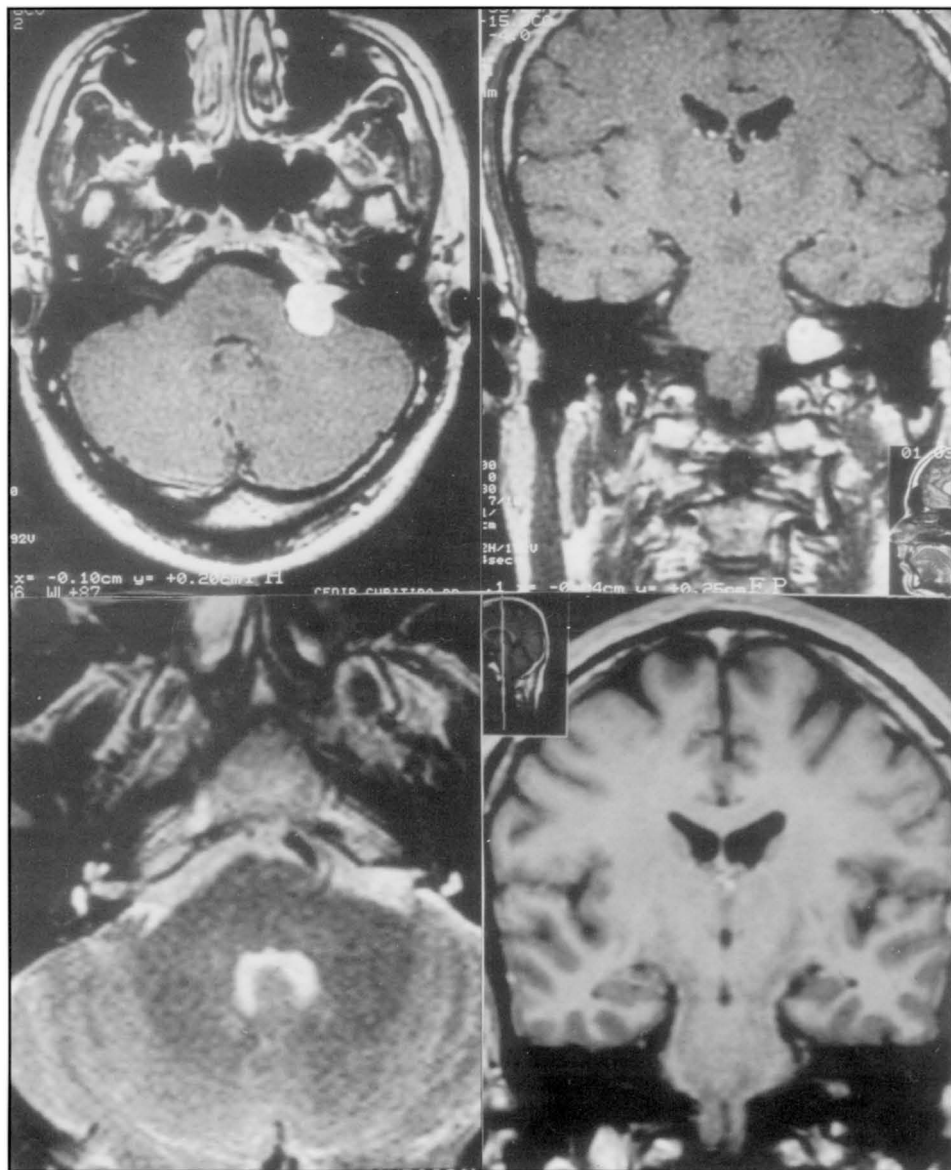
Upper: Preoperative MRI examinations (T1 with gadolinium) showing an acoustic neuroma with 2.0 cm. Below: Postoperative MRI examinations (left T2 and left T1 with gadolinium) after total removal of the lesion with preservation of cranial nerves VII and VIII. The facial and cochlear function could be preserved in this case.
